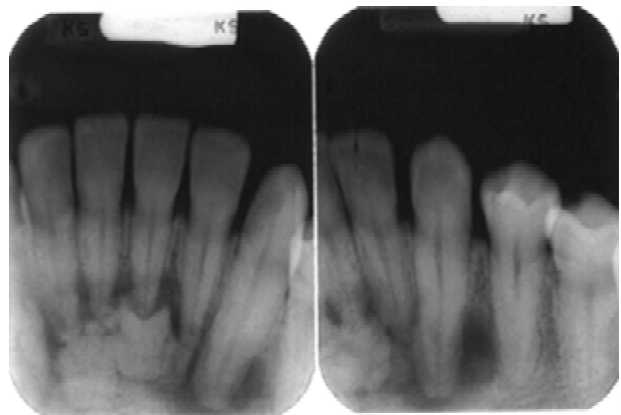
Periapical OD. Mixed radiolucent/radiopaque lesions in apical region of anterior mandible.
